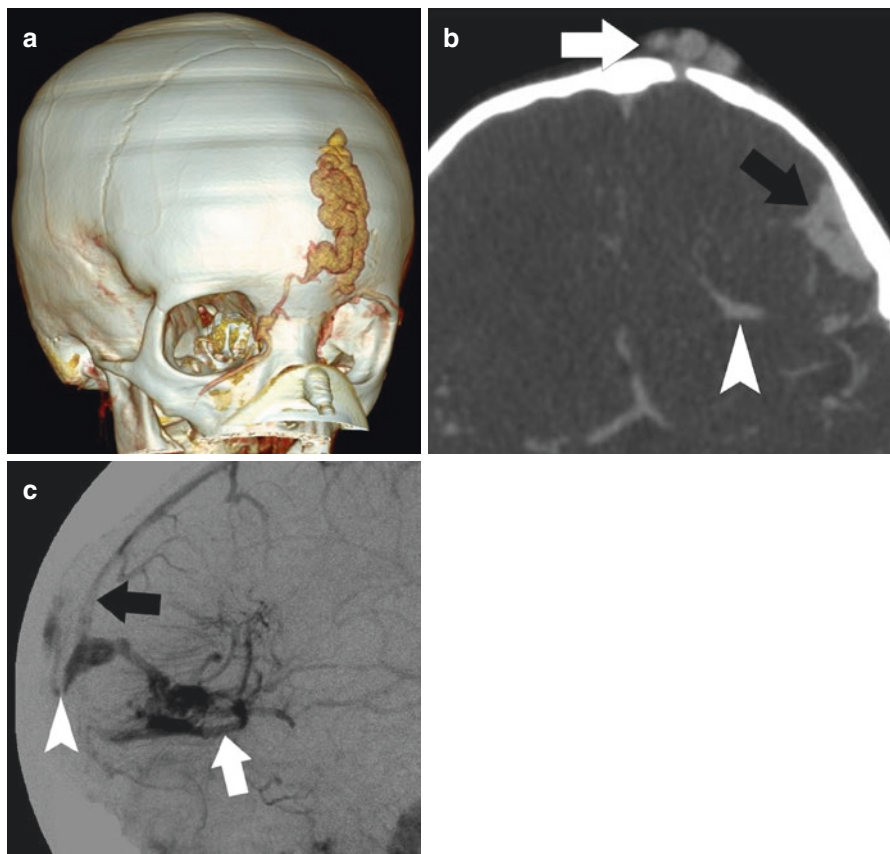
Three month old with a frontal sinus pericranii. (a) Volume-rendered 3DCT angiography shows a tangle of vessels in the frontal soft tissues. Communications with right frontal and angular veins and left supraorbital vein are partially seen. (b) Axial CT angiography shows the epicranial pouch (*white arrow*) with a small vein crossing the calvarium. Note a developmental venous anomaly (*arrowhead*) and a prominent varicosity in the left frontal region (*black arrow*). (c) Lateral digital subtraction angiogram shows a complex developmental venous anomaly with two collecting vessels (*white arrow*). There is drainage to both the superior sagittal sinus (*black arrow*) and veins in the frontal soft tissues through a trans-osseous channel (*arrowhead*)
